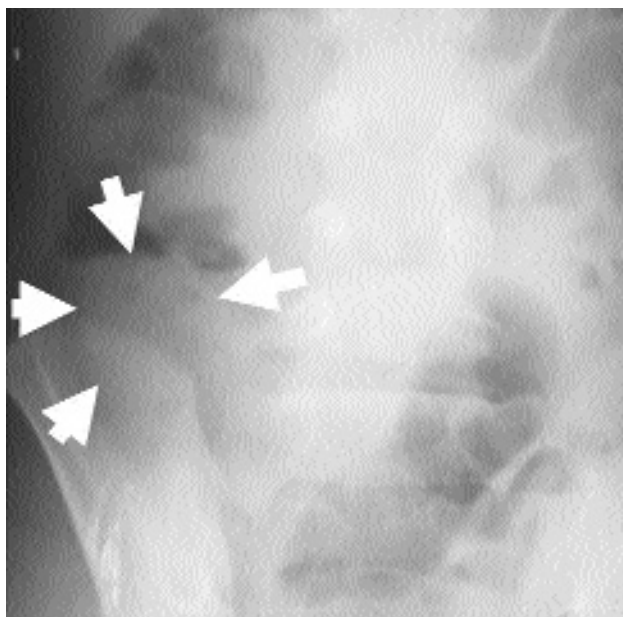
(a) Plain abdominal radiography (PAR) view of DTC (arrow) sign and a calcified fecalith (dashed arrow); (b) DTC sign (arrows) and RLQ single air fluid level (dashed arrows); (c) DTC sign (arrows), localized extraluminal air (dashed arrows), and a calcified fecalith (arrow heads). Black arrows indicate two artifacts; (d) a calcified lamellated fecalith (dashed arrow) and multiple air fluid levels (arrows); (e) multiple air fluid levels (arrows).
